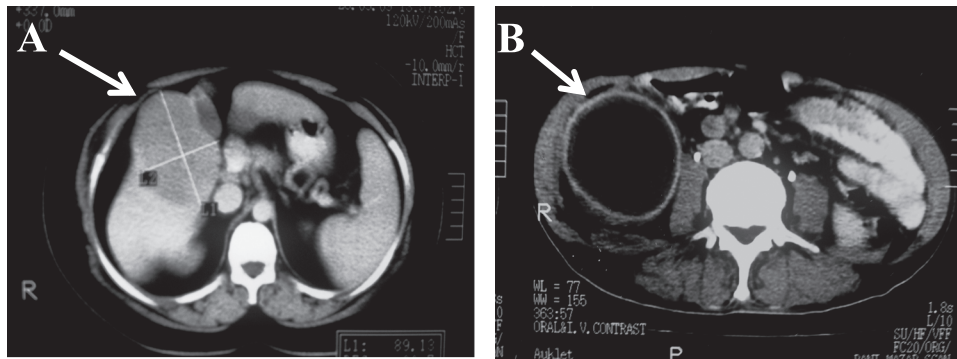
CT scan of a hydatid cyst. (A) Hydatid cyst in the liver of case 5. A mass with homogeneous density (white arrow) is depicted in the right lobe. (B) Hydatid cyst in the peritoneum of case 21. The white arrow indicates a round lesion.
